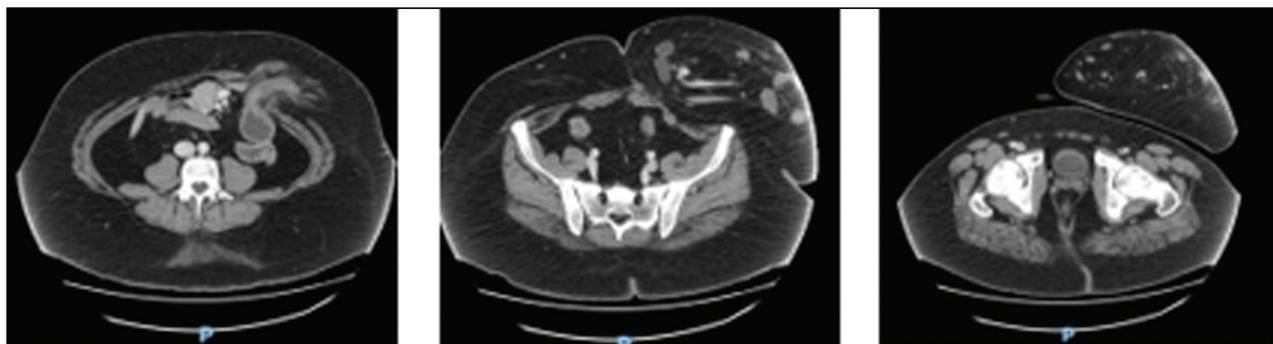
Coronal section of the computed tomography scan from the proximal to distal abdominal wall demonstrating the hernial sac with intestinal contents
